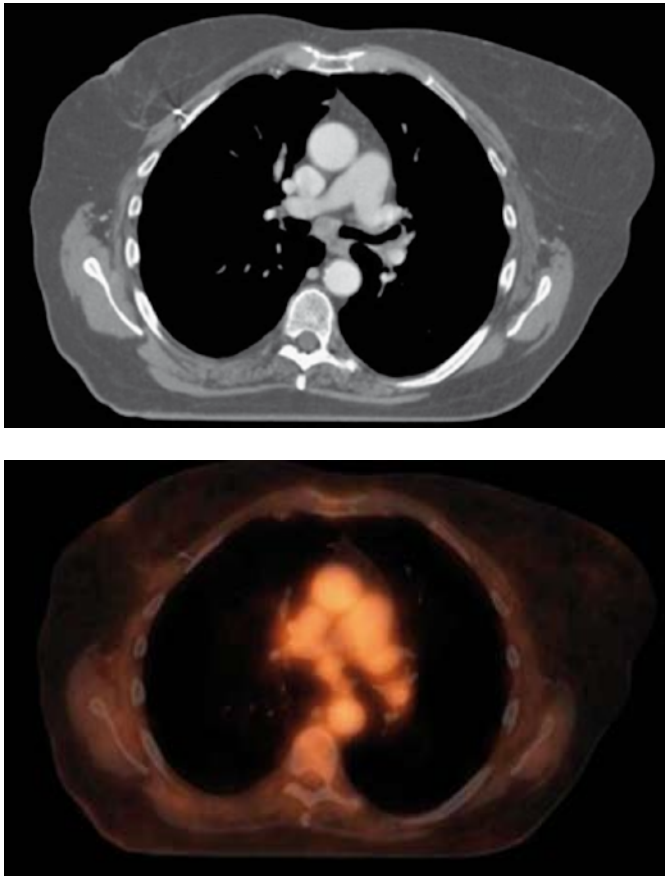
Non-small cell lung cancer. Axial view of  $^{18}\text{F}$ -FDG PET-CT with contrast. CT shows an enlarged node (level 7, diameter of 1.9 cm), while PET shows no FDG uptake in level 7. This finding influences the delineation of the nodal target volume.
